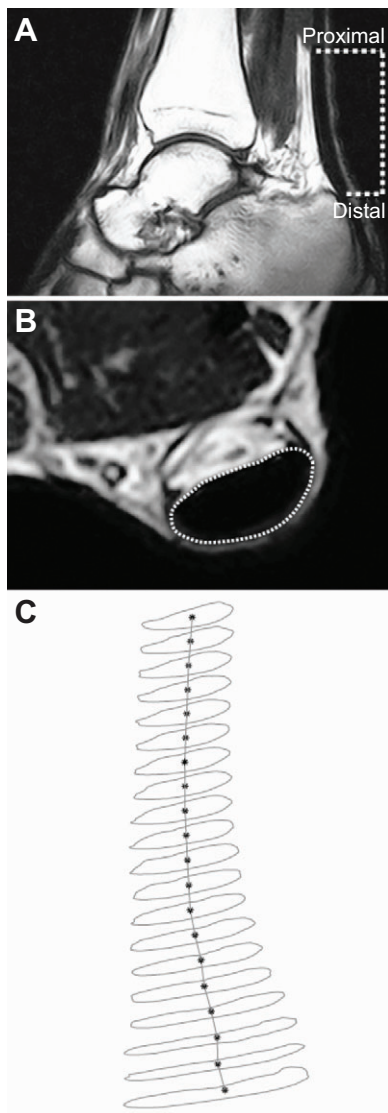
Magnetic resonance images of the free AT. Sagittal (A) and transverse (B) images were used to investigate morphological AT properties (i.e. length and CSA; C). Transversal images served to detect the proximal (m. soleus–AT junction) and distal (initial attachment on the calcaneus bone) border of the free AT (A). Sagittal images within this range were segmented to determine the CSA (B) and to calculate the tendon length (i.e. the curved path through the CSA centroids; C).
